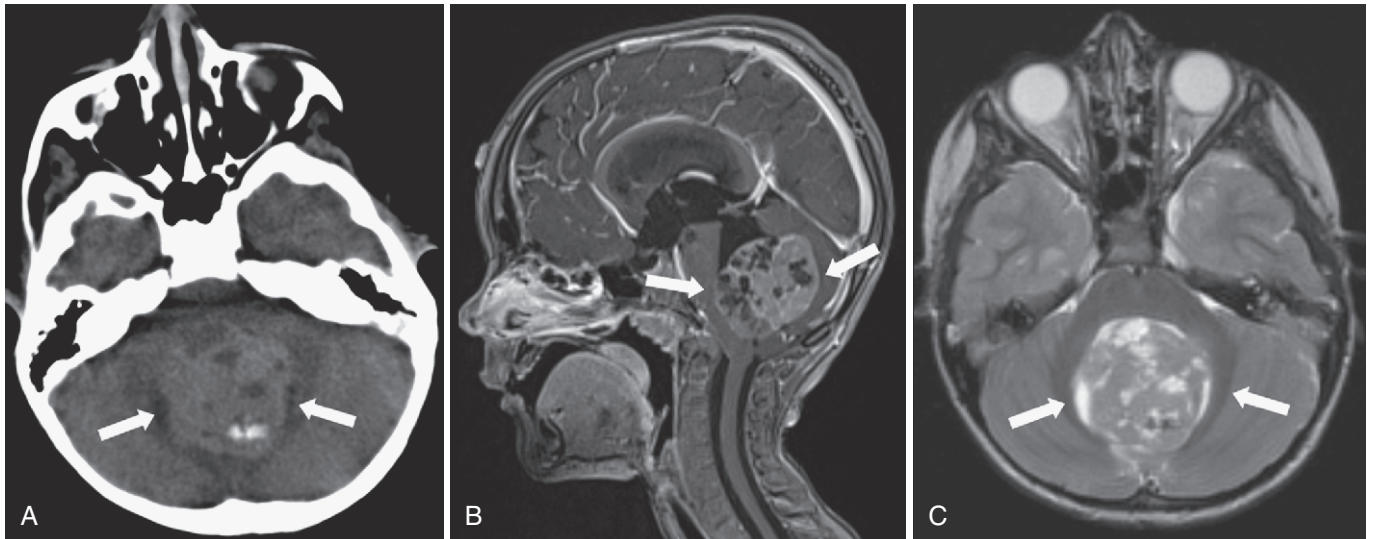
Posterior fossa medulloblastoma. Axial noncontrast CT (A) and sagittal T1-weighted MRI with gadolinium (B) show a midline posterior fossa mass that has heterogeneous enhancement on postcontrast T1 and heterogeneous signal on axial T2-weighted MRI (C).
